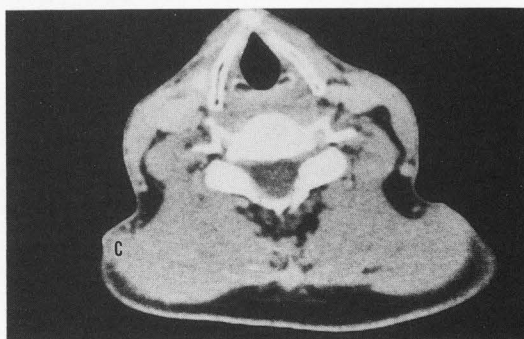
A, C; No significant findings not only on MRI but also on CT.
